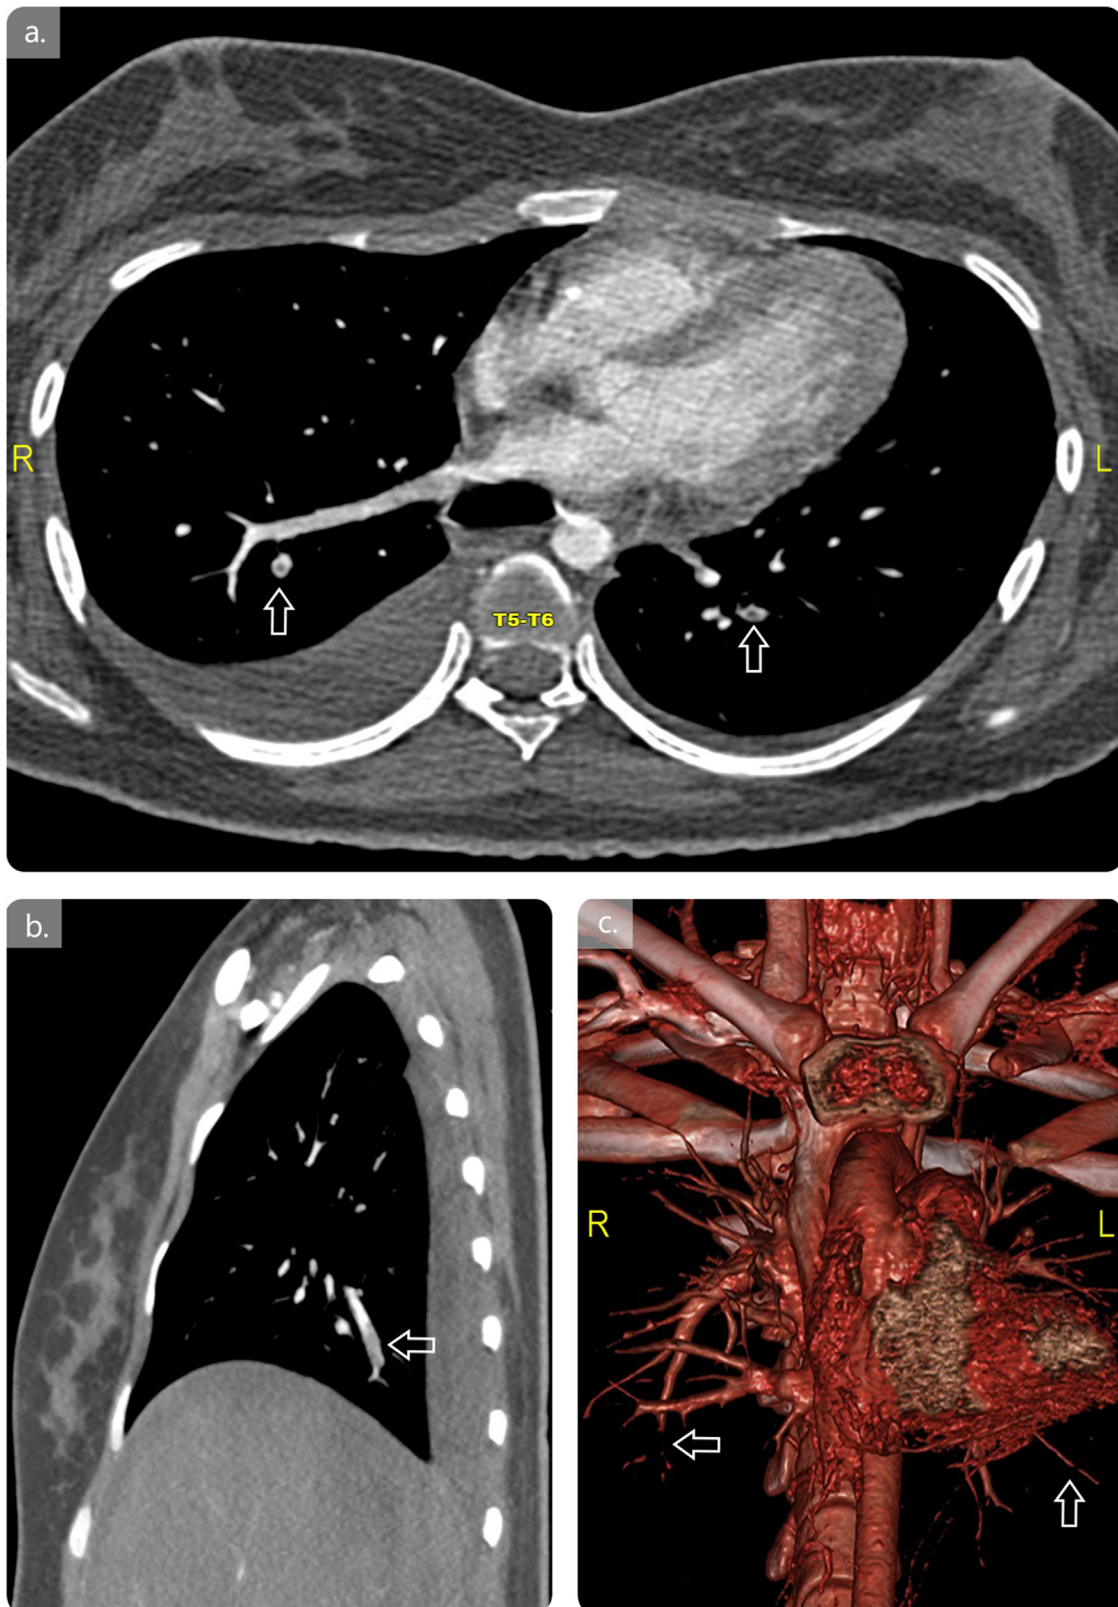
CT angiogram of the chest.
